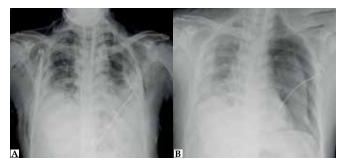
Chest radiograph (postero-anterior view) showing (A) bilateral basal infiltrates and (B) left sided pneumothorax, with collapsed underlying lung border.
